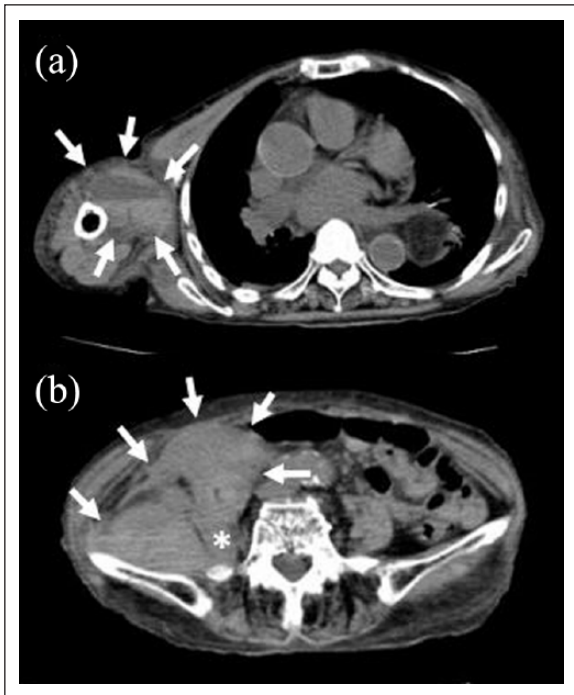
Plain computed tomography (CT) images of the right biceps brachii and abdomen on Day 12. (a) An intramuscular hematoma containing fluid–fluid levels (surrounded by white arrows) is visible in the right biceps brachii. The patient’s right arm was pulled down to obtain these images because severe pain prevented her from lifting it. (b) A massive hematoma (surrounded by white arrows) is visible in the retroperitoneal space at the height of the aortic bifurcation and adjacent to the ileum and right iliopsoas muscle (asterisk).
